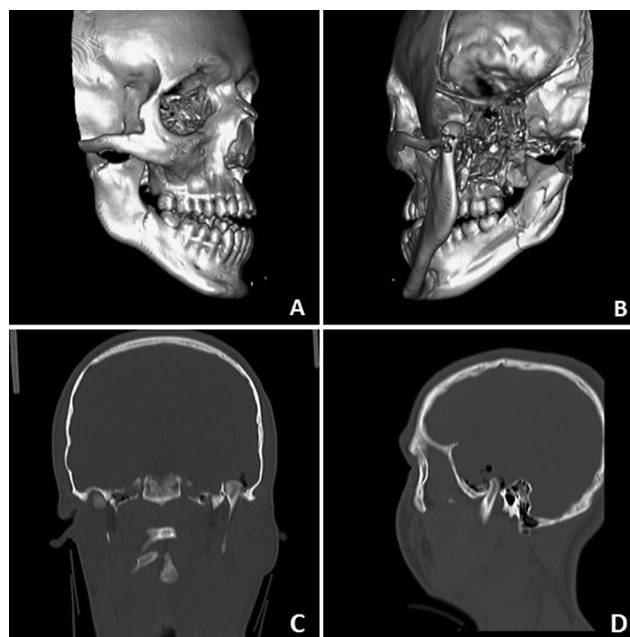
Computed tomography (CT) in the three-dimensional (3D) reconstruction (A, B) showing incomplete fracture of the right condyle, right angle fracture, and left condyle displaced into the cranial fossa, in the sagittal and coronal views. (C, D) Visualization of the foci of pneumocephalus and fracture of the glenoid fossa.
